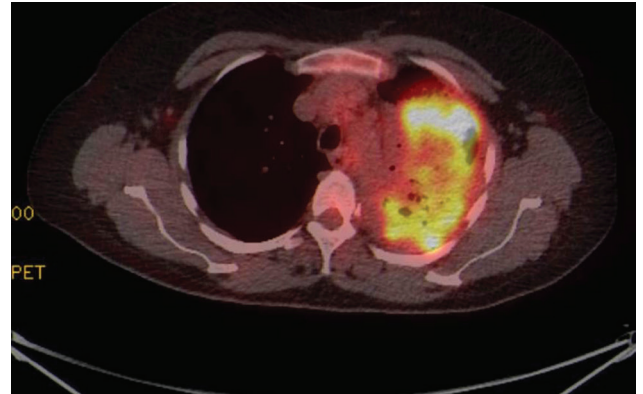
CT scan of the thorax performed during investigation
